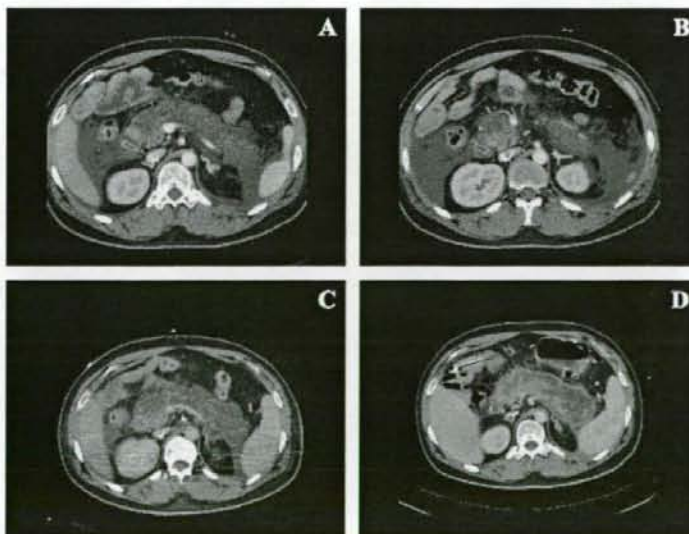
Computed tomography-scan images of pancreatitis. Upper panels (A and B) indicate enhancement only in the pancreas head, and the presence of peripancreatic fluid on day 14. Decreased peripancreatic fluid seen on day 19 (C). The boundaries of pancreas are enhanced and a naso-jejunal tube is seen on day 27 (D).
